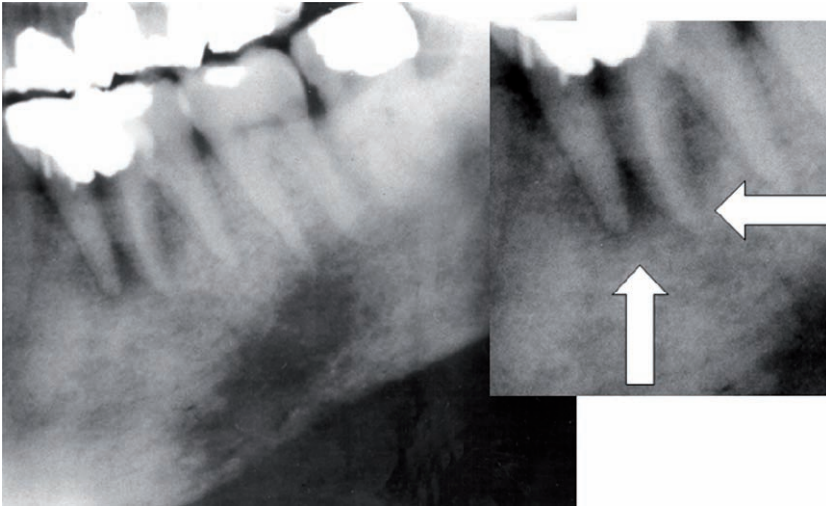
Metastatic carcinoma. Note irregular “moth-eaten” rarefaction adjacent to first molar and second premolar teeth (detail from panoramic radiograph). Using the narrower perspective of a periapical radiograph, this lesion could well be misinterpreted as a simple “endo-perio” case
